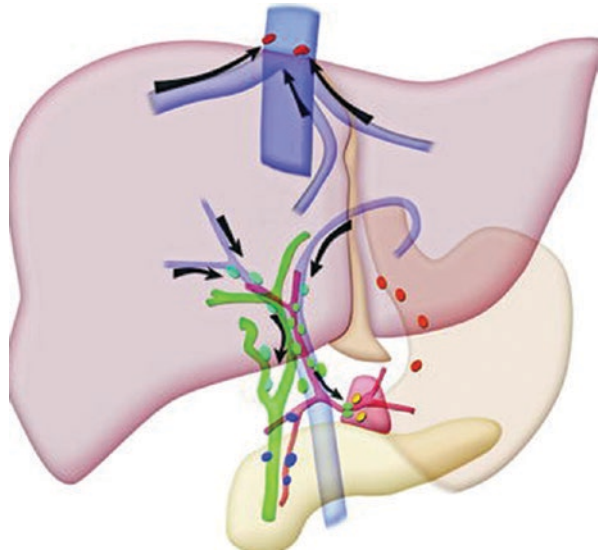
(a, b) Axial CT image in a patient with hepatocellular carcinoma shows enlarged hyper-vascular nodes (green) in the periportal locations
